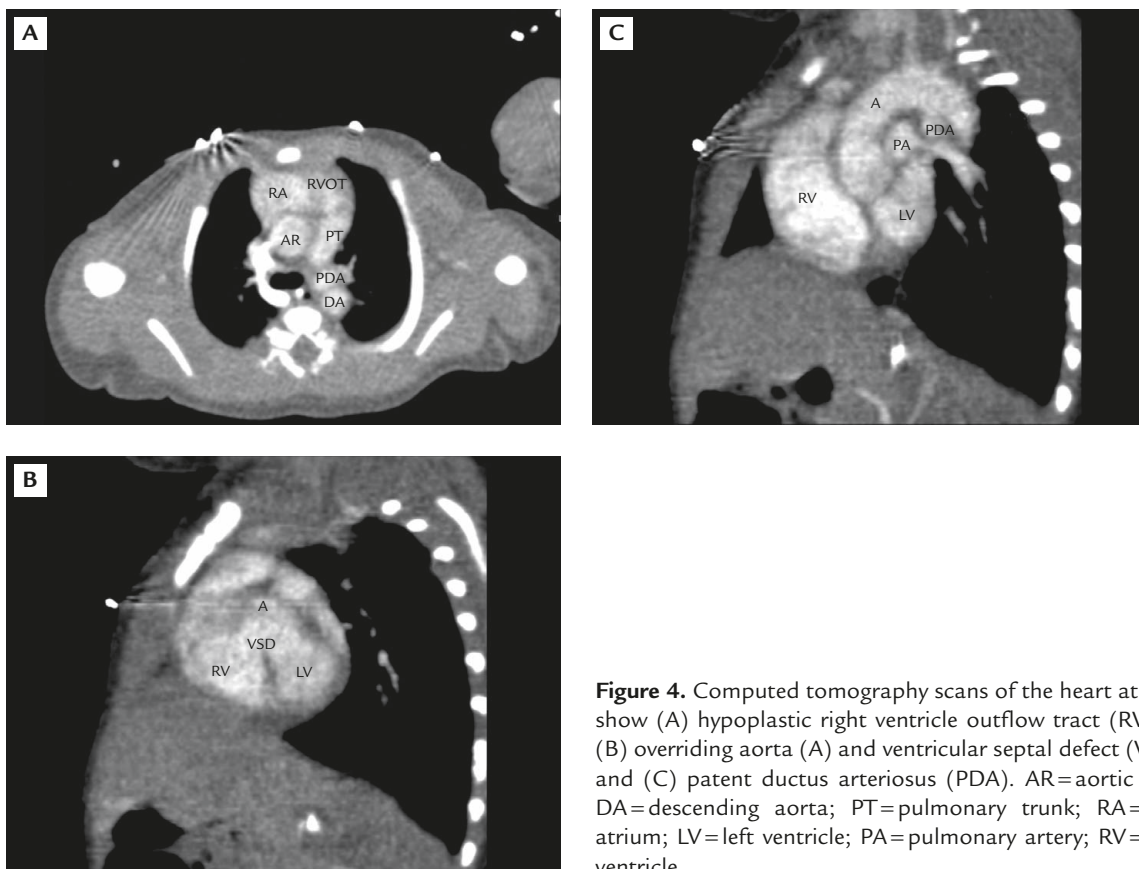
Computed tomography scans of the heart at birth show (A) hypoplastic right ventricular outflow tract (RVOT); (B) overriding aorta (A) and ventricular septal defect (VSD); and (C) patent ductus arteriosus (PDA). AR=aortic root; DA=descending aorta; PT=pulmonary trunk; RA=right atrium; LV=left ventricle; PA=pulmonary artery; RV=right ventricle.
